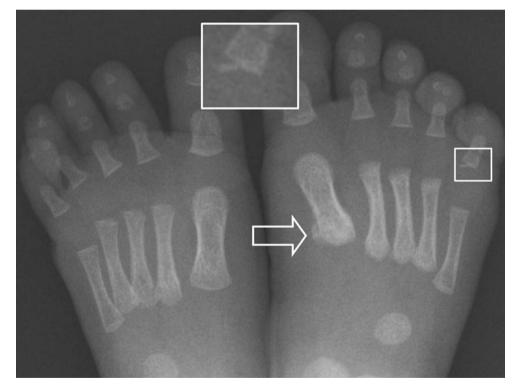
Two-month-old infant who was suspected to be a victim of child abuse. As part of the skeletal survey radiographs of the feet were made, these showed a torus fracture of the base of MT-I of the right foot (arrow) and a SH-III fracture of the base of the proximal phalanx of the 5th toe (inset)
